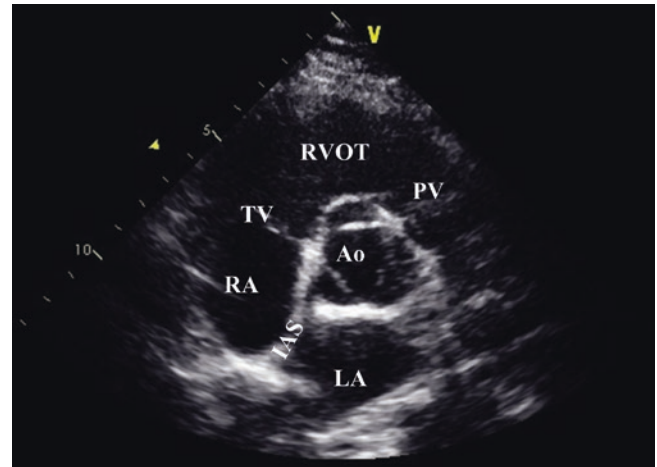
Parasternal short axis view at the level of the aortic valve. The short axis view of the aortic valve is obtained and all three leaflets of the aortic valve (Ao) are seen in the middle. This view also allows identification of right ventricular outflow tract (RVOT), right atrium (RA), left atrium (LA) and interatrial septum (IAS), tricuspid valve (TV) and pulmonary valve (PV)
